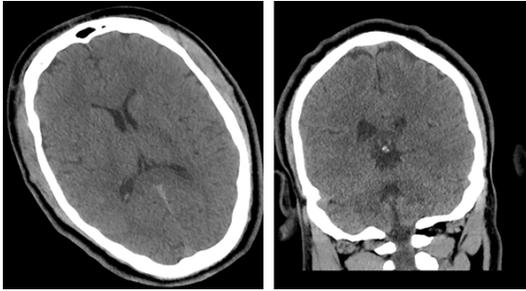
Brain CT at the time of the admission showing normal findings.
